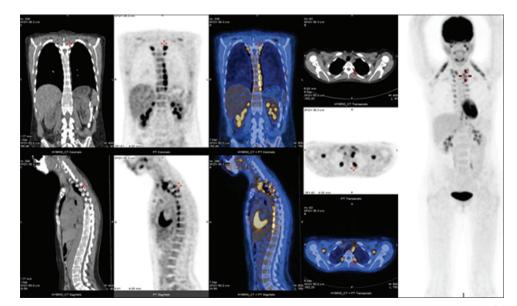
Maximum intensity projection, axial, coronal and sagittal images of fluorodeoxyglucose positron-emission tomography/computed tomography study of a 30-year-old female with Hodgkin's lymphoma showing activated supraclavicular and paravertebral brown adipose tissue with diffuse intense myocardial uptake
